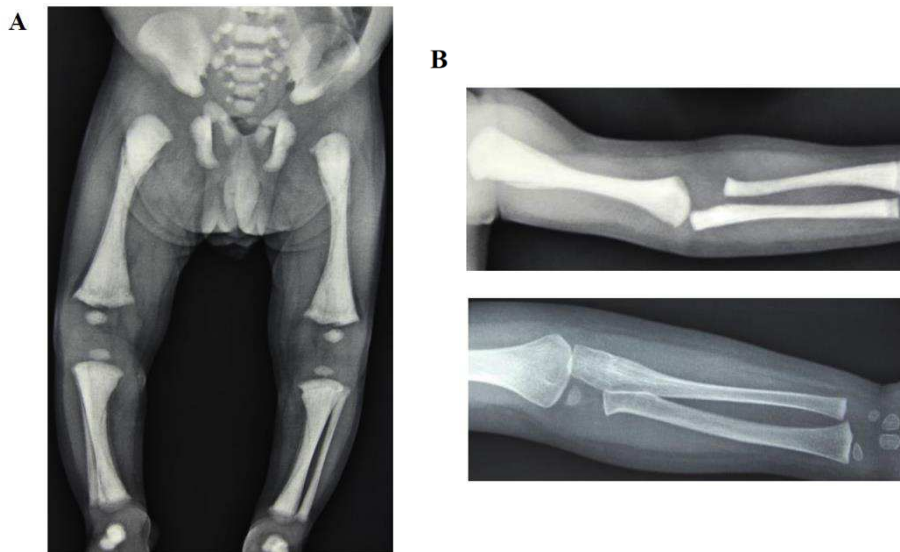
Representative radiographs of Pt 2 showing (A and B, upper panel) diffuse increase in bone density compatible with osteopetrosis diagnosis; (B, lower panel) complete restoration of bone phenotype and marrow cavity after transplantation.
